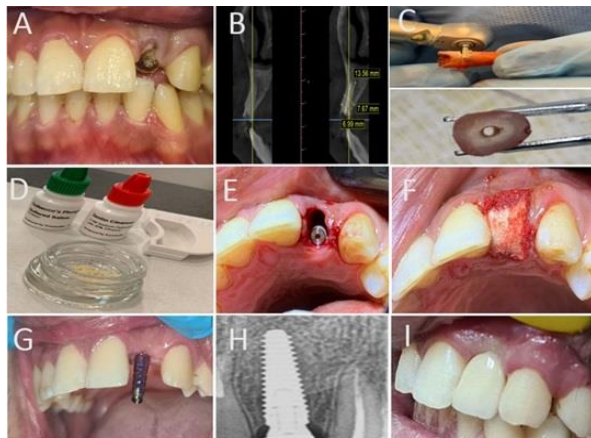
A detailed case of immediate dental implant insertion with an autogenous dentin graft and subsequent prosthetic part loading and evaluation of the Pink Esthetic Score (A) a preoperative view of the non-restorable maxillary left lateral incisor; (B) an axial view of CBCT showing the accused retained root and the surrounding bone; (C) preparation of the extracted retained root before grinding; (D) treating the resulting autogenous dentin particles with cleanser and neutralizer solutions; (E) dental implant placed in the palatal position with a labial jump distance to be filled with the graft; (F) placement of the gel foam plug over the implant and the graft; (G) impression post placed in the second stage of treatment; (H) periapical x-ray showed osseointegration around the dental implant after six months from the initial operation; (I) final clinical view of the implant-supported crown at the time of insertion.
